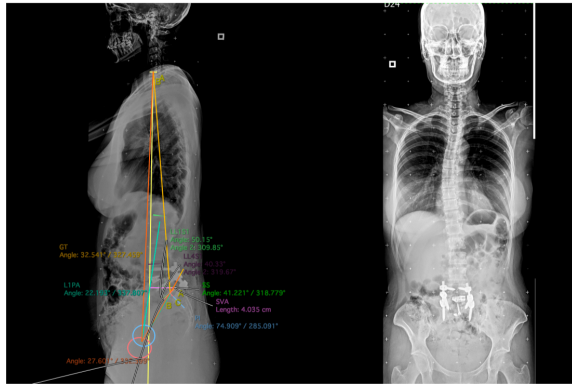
Postoperative panoramic X-ray showing improvement in the sagittal balance and lumbar lordosis gain.
